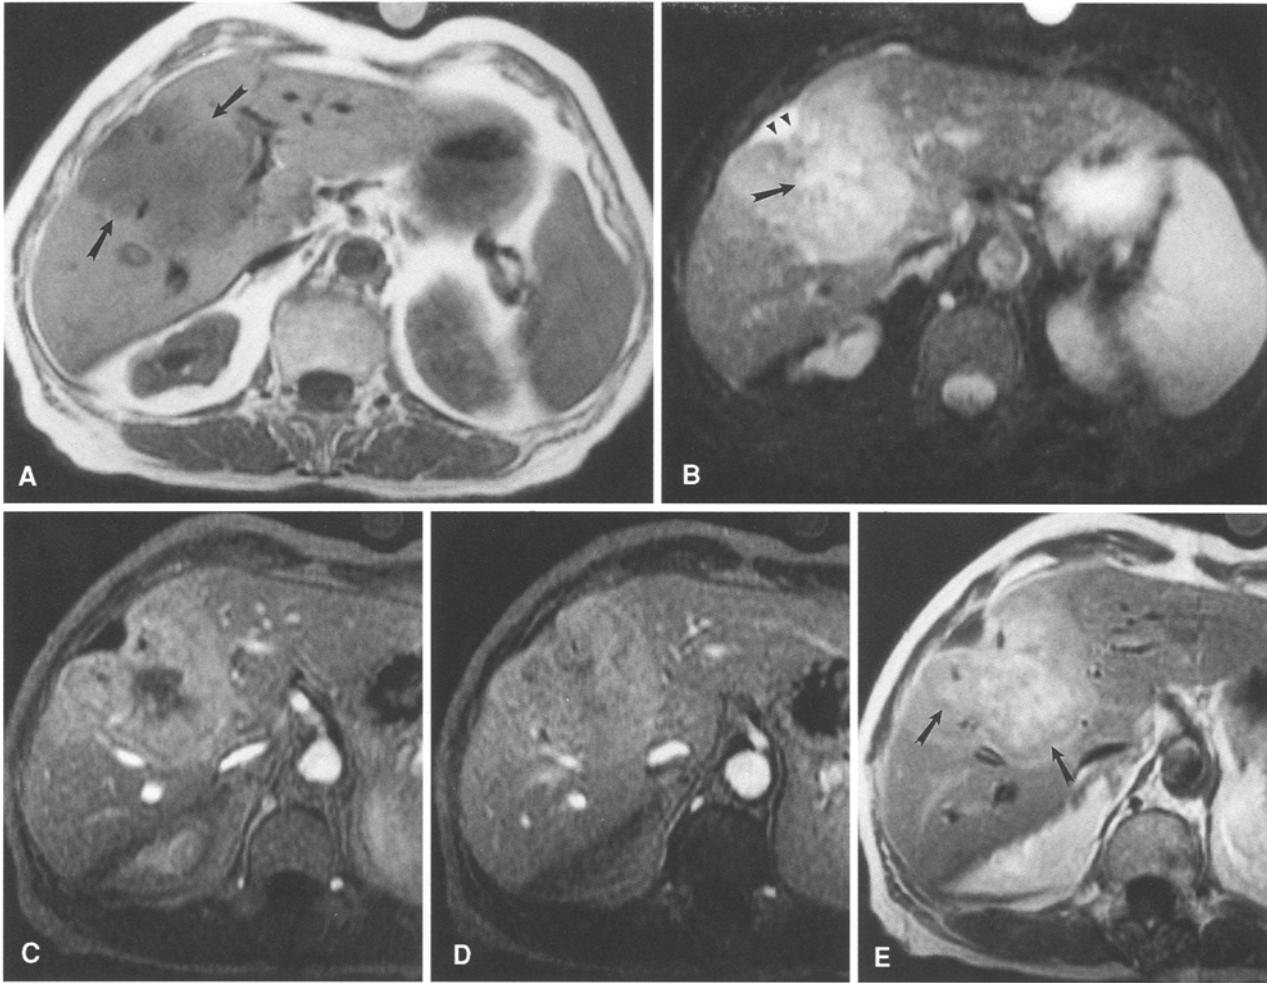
A 72-year-old woman with intrahepatic cholangiocarcinoma. A T1-weighted (TR/TE = 450/15 ms) spin-echo (SE) MR image shows hypointense well-defined intrahepatic tumor (*arrows*). B T2-weighted (TR/TE = 2500/80 ms) SE MR image shows hyperintense well-defined tumor. A hyperintense central scar is seen (*arrow*). Retraction of the liver capsule adjacent to the tumor is present (*arrow-heads*). C Gradient-recalled echo (FSPGR, TR/TE = 11/4 ms, flip
